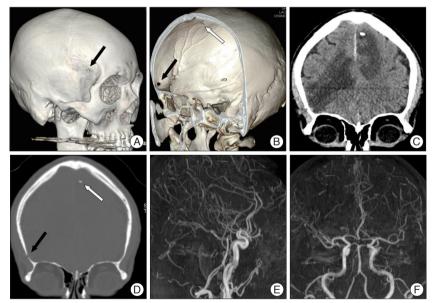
Facial computed tomography (CT) with 3 D reconstruction images and CT angiography. A and B : Facial bone CT revealing small bony defect (black arrow) at greater wing of right sphenoid bone and small bone fragment (white arrow) at left frontal region. C and D : Coronal tilting reconstruction images shows resolution state of intracerebral hemorrhage, and both bony defect (black arrow) and small bone fragment (white arrow). E and F : Computed tomographic angiography showing no definite vascular abnormality.
